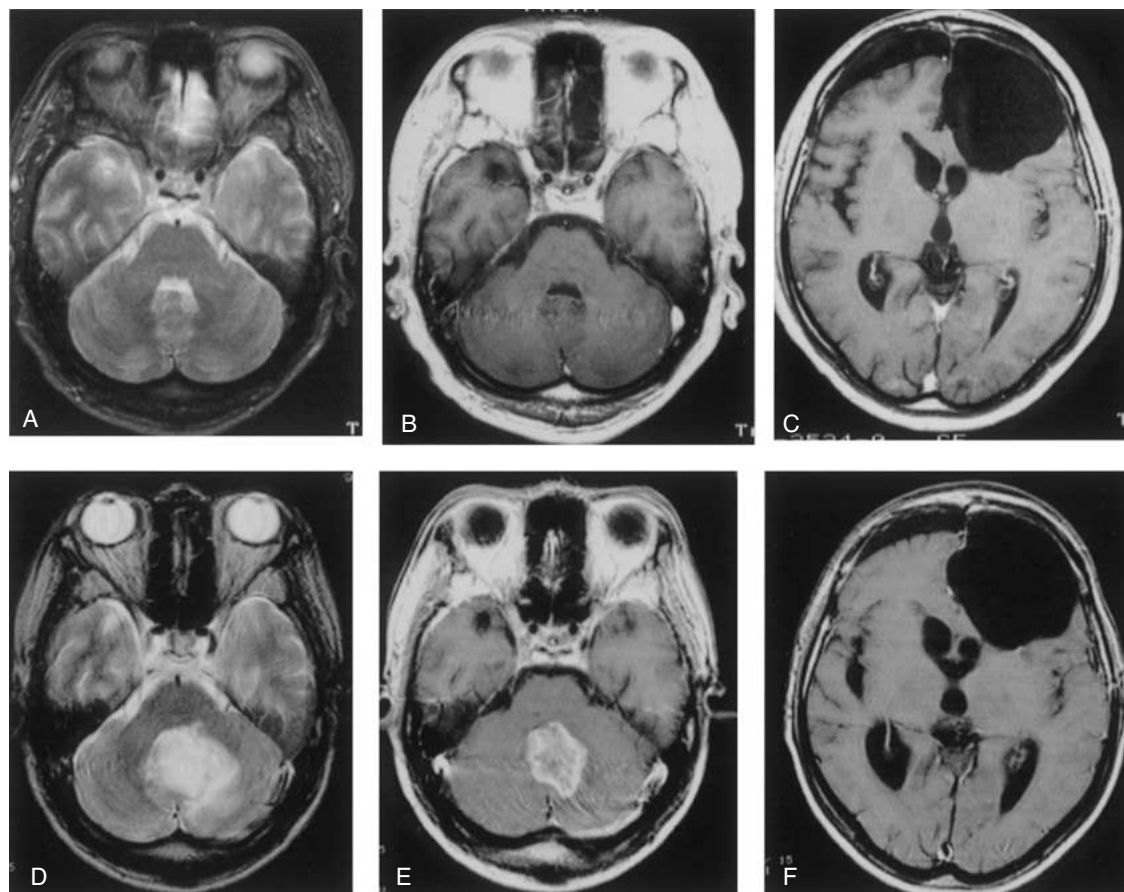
Case 1. T2-weighted (A, D) and T1-weighted MR images with gadolinium-diethylenetriaminepenta-acetic acid (Gd-DTPA) (B, C, E, F). The CSF seeding was not evident around the fourth ventricle 1 month after presentation with intractable vomiting (A–C), but appeared 2 months later (D–F).
